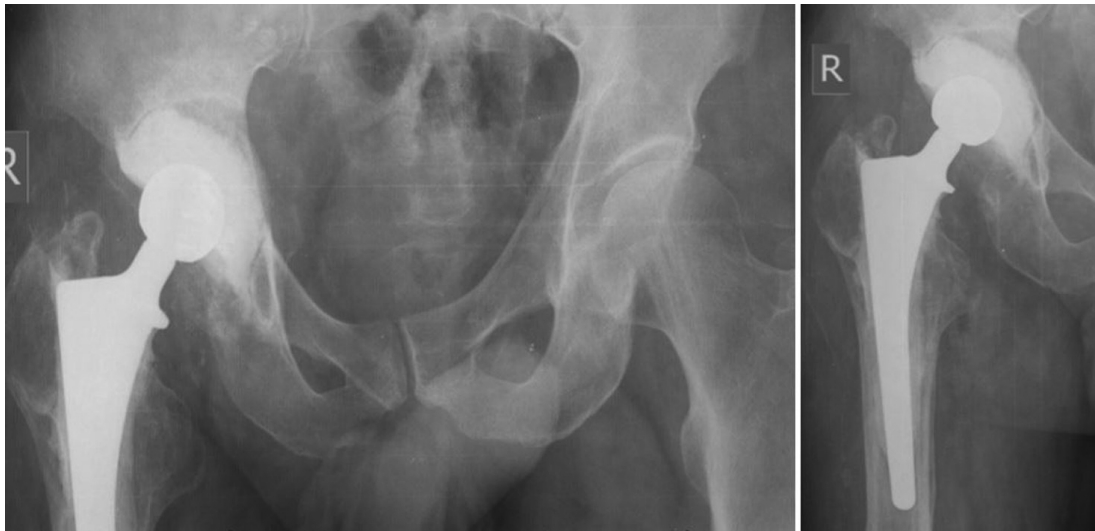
Radiographs of the pelvis and right hip joint 1 month after the intervention
